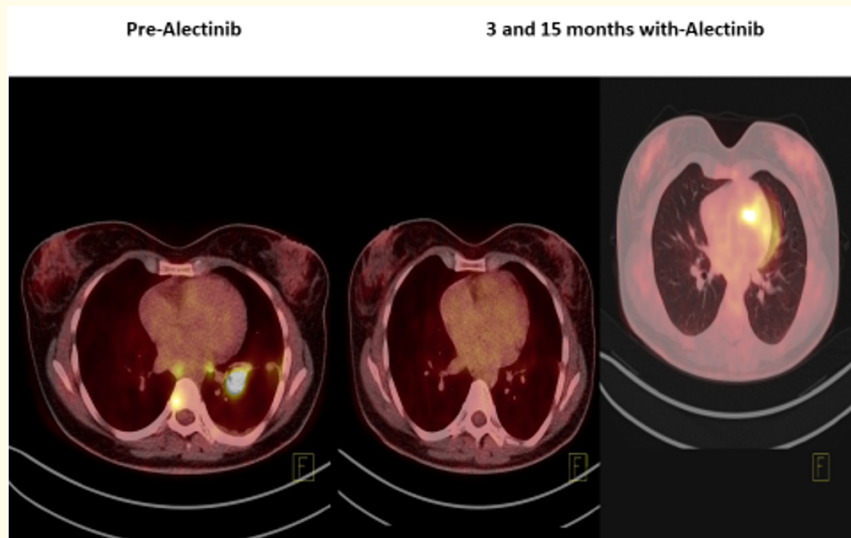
Complete tumor response et the 36 years old women after 3 and after 15 months of treatment with alectinib-PET/CT transversal view.
